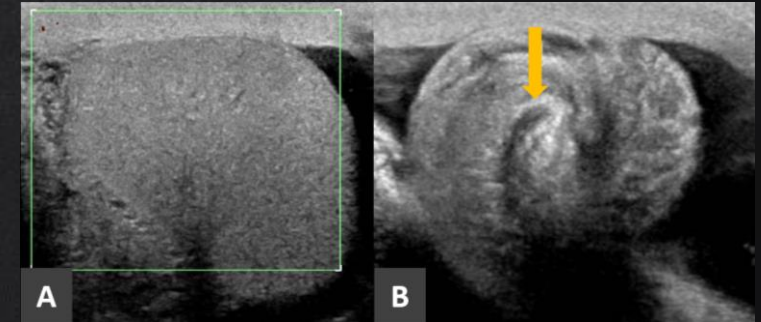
25-year-old man with right testicular torsion evidenced by absence of Doppler flow (A) and twisted spermatic cord showing concentric pattern on the grayscale (B) - (yellow arrow).
